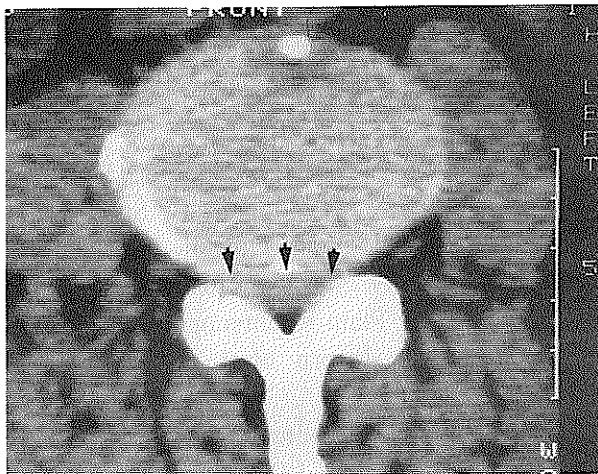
至 Fig.8 CT scan finding
